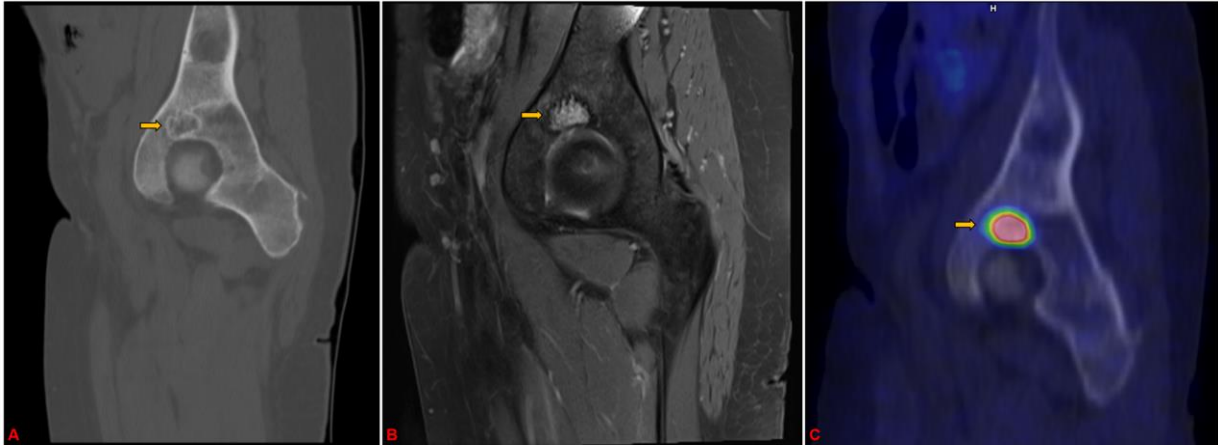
Presumed 13 mm phosphaturic mesenchymal tumour in the right acetabulum with sagittal views. A: Computed tomography. B: Fat suppressed proton density weighted magnetic resonance imaging. C: Gallium-68 DOTATATE positron emission tomography.
